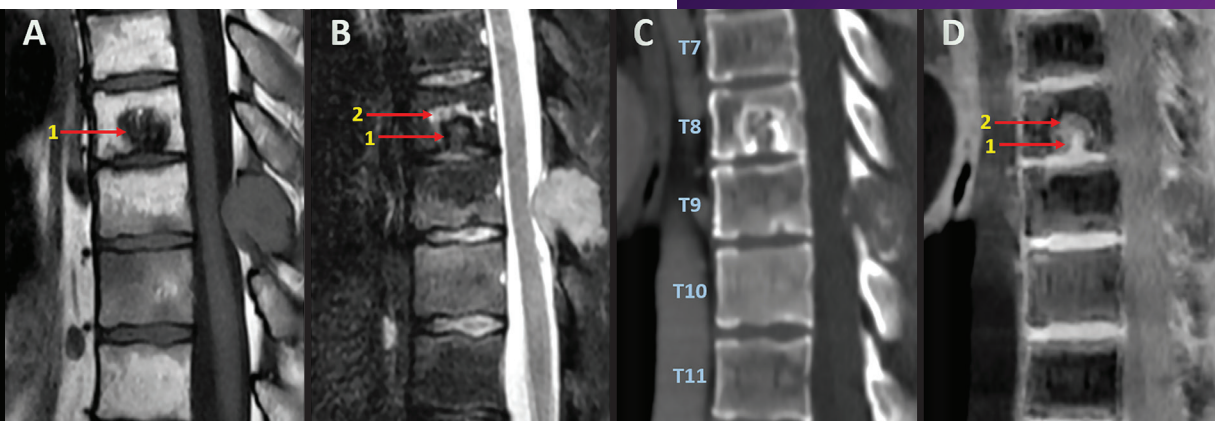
Figure A Sagittal (T1) MRI image shows T8 vertebral metastasis (arrow 1).
